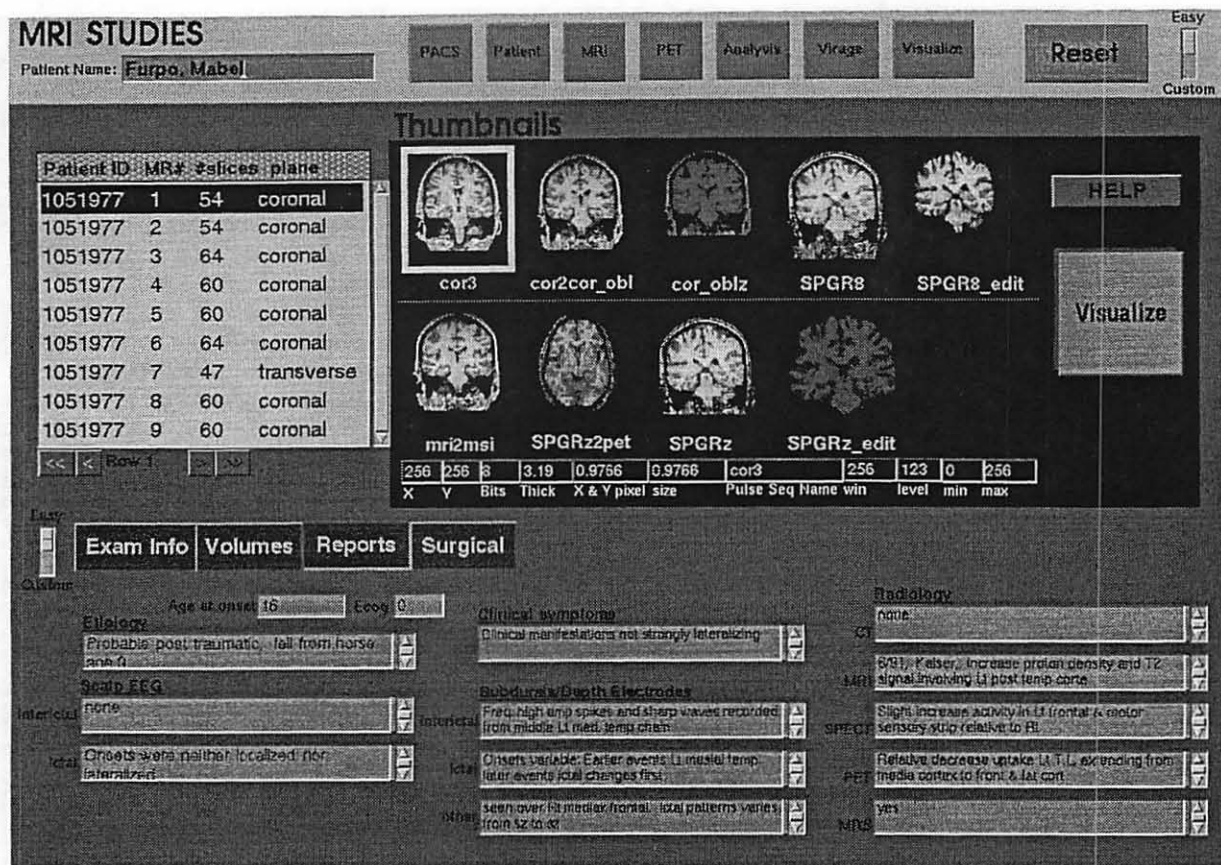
GUI to relational database. Queries on image features and textual keywords is supported. Clicking on thumbnails triggers retrieval of full MRI dataset. Textual data is displayed in text widgets below.
